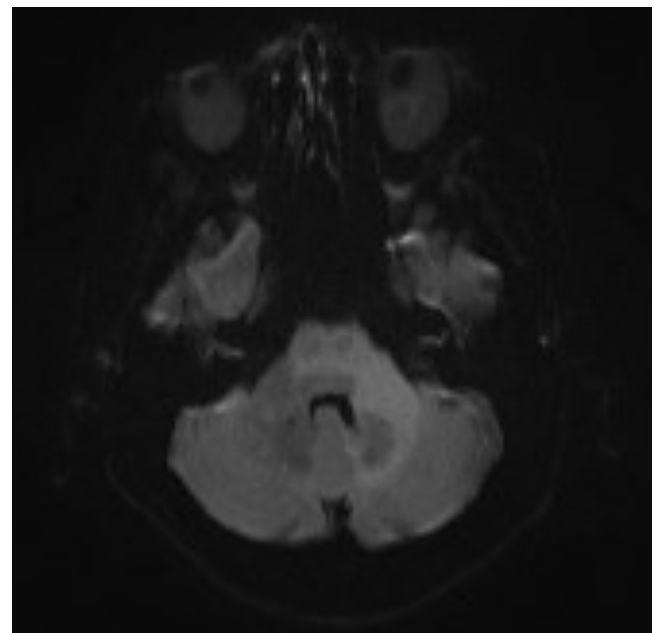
Brain magnetic resonance imaging, diffusion weighted images sequences: increase of signal in the same regions without detectable apparent diffusion coefficient changes
